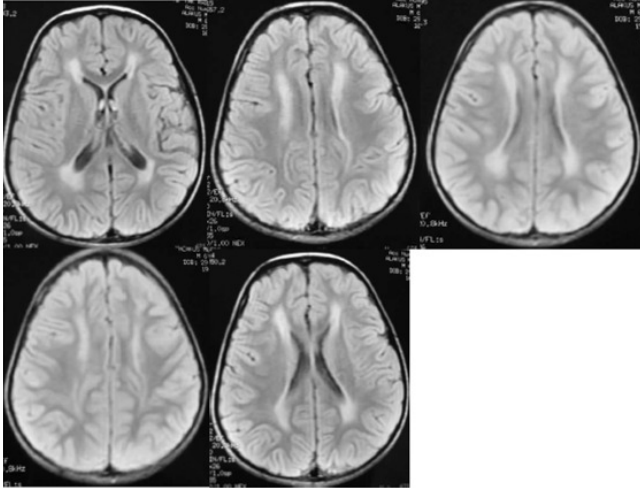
Axial FLAIR images show symmetric increased signal intensity in the cerebral white matter. (periventricular, subcortical and supratentorial localized).
